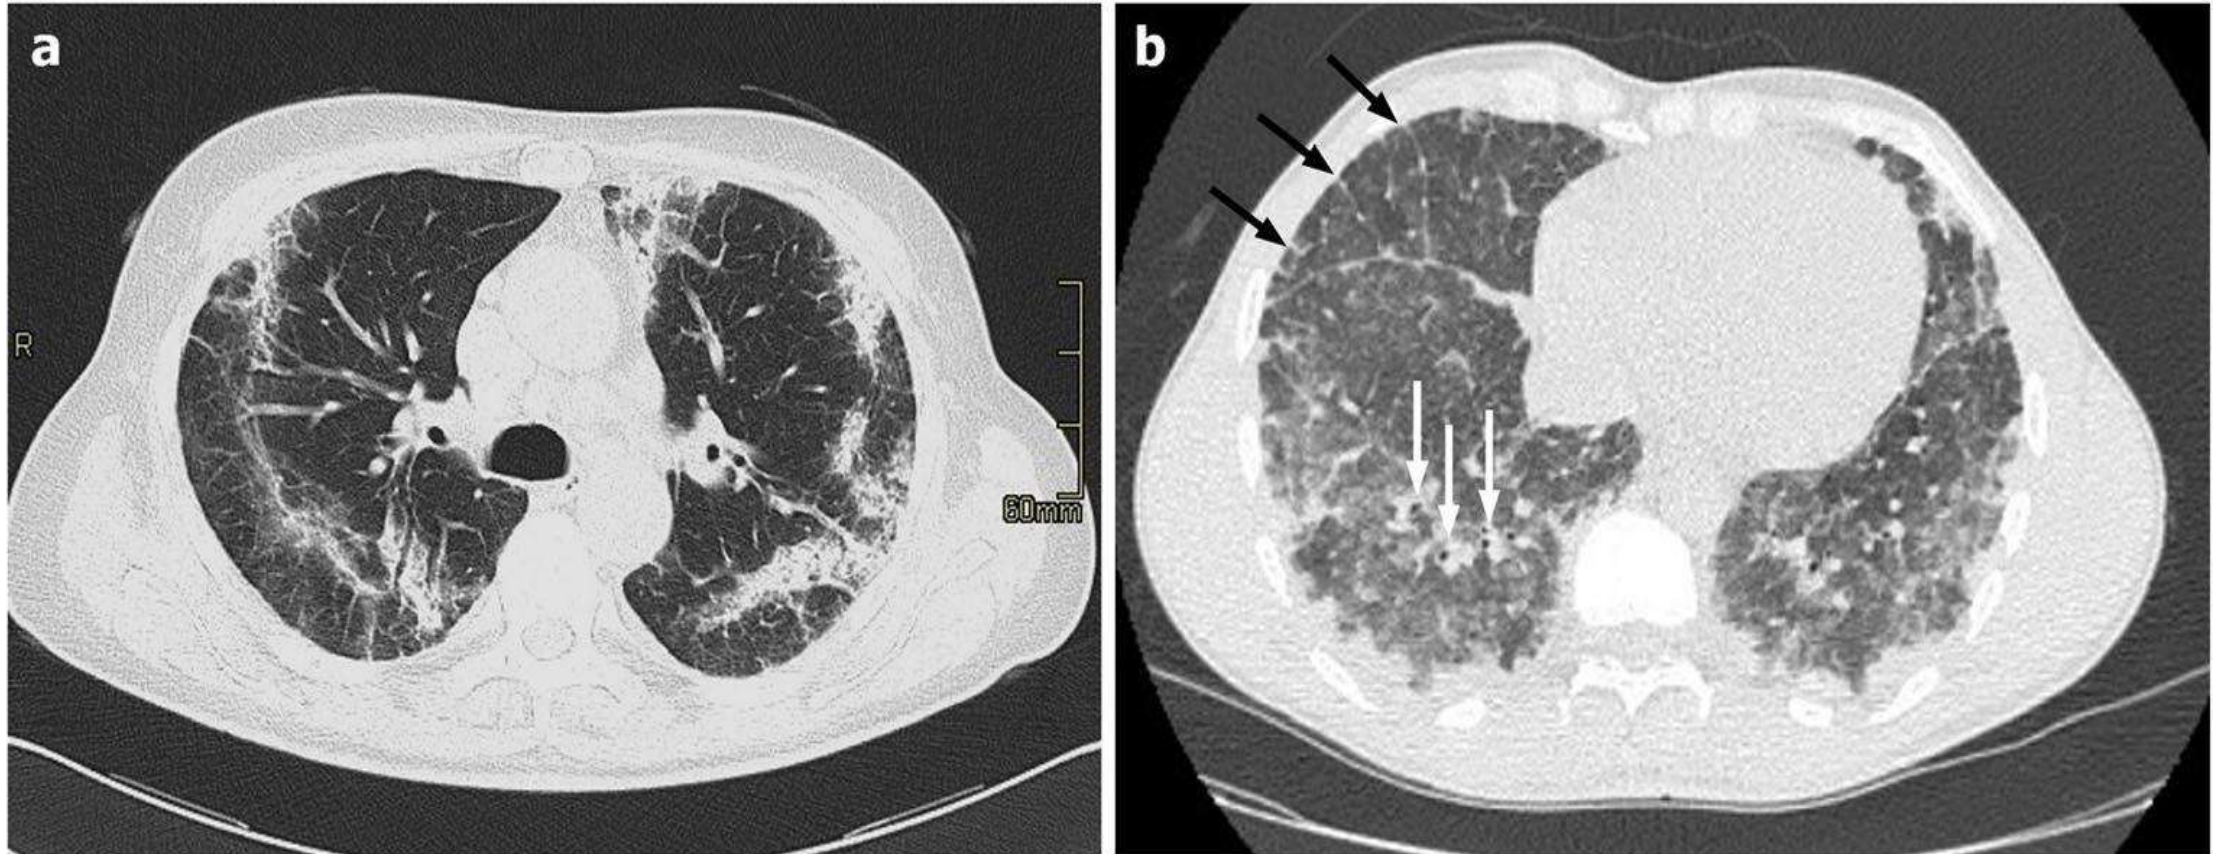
a–b Axial HRCT images of two patient with acute eosinophilic pneumonia (a–b) show parenchymal ground-glass opacities and consolidations with a peripheral and lower lobes prevalent distribution; thickening of interlobular septa (black arrows in b) and broncho-vascular bundles (white arrows in b) are also seen
